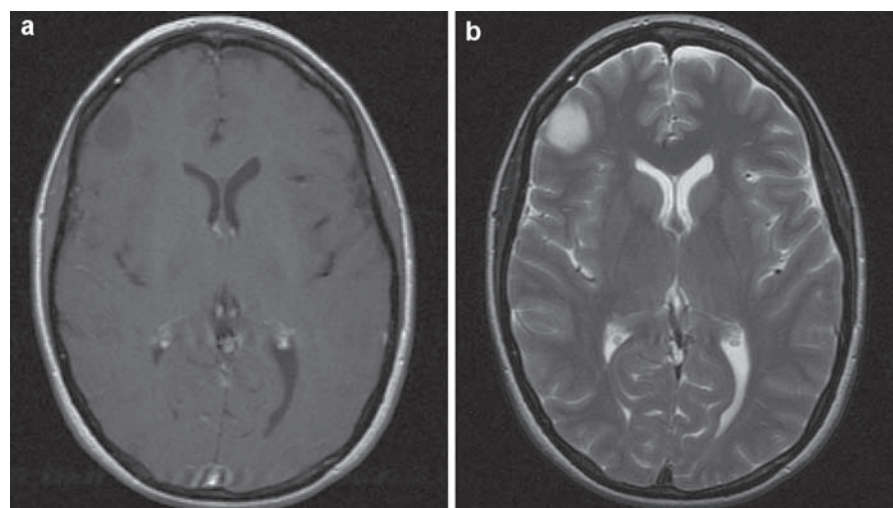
T1-weighted, axial (a) and T2-weighted, axial (b) magnetic resonance imaging of a non-contrast-enhancing, low-grade astrocytoma in a 41-year-old female patient
